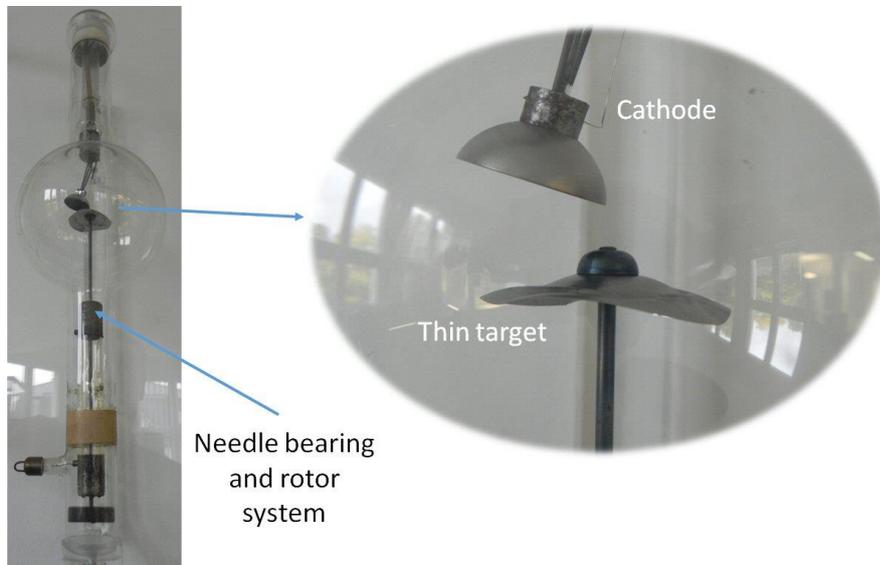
Experimental rotating target tube from 1927 by PhönixRöntgenröhrenfabriken AG, Rudolstadt, Germany, later Siemens. (Picture taken in the Siemens X-ray tube museum Rudolstadt, Germany.)
